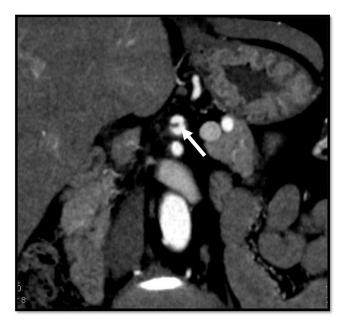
The contrast medium-enhanced computed tomography angiography (CTA) of the celiac artery (CA): coronary section. Arterial dissection begins from the root of celiac artery and the entry site could be confirmed. A false lumen was observed on the leg side (white arrow).
